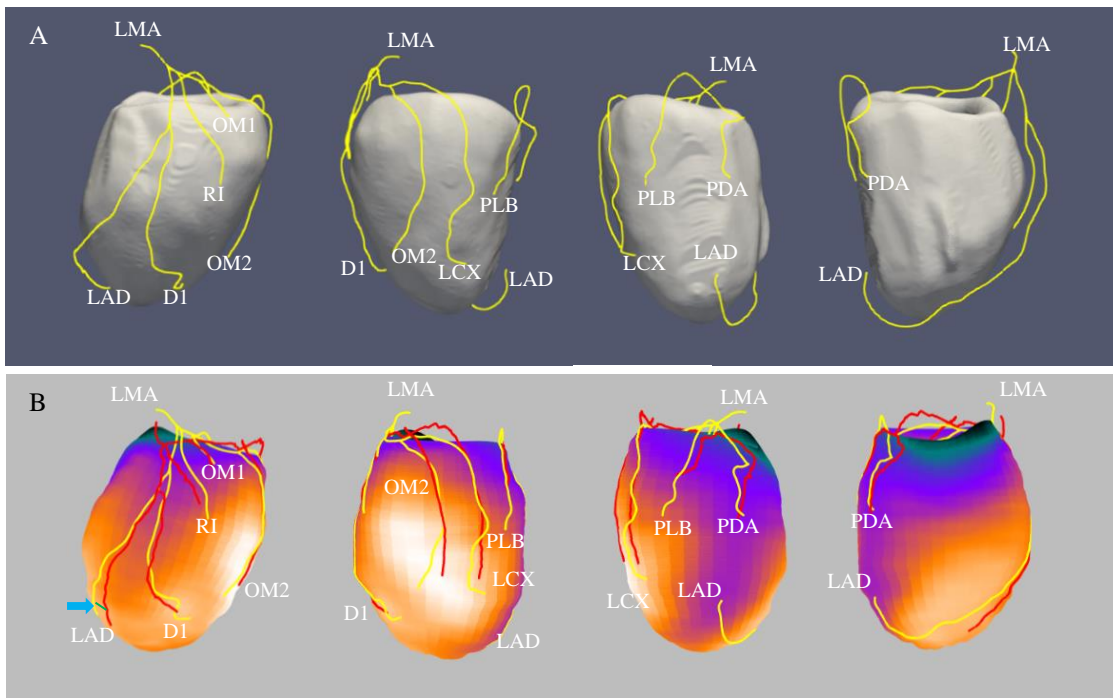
Comparison between fluoroscopy and CT arteries on SPECT LV epicardial surface.*
